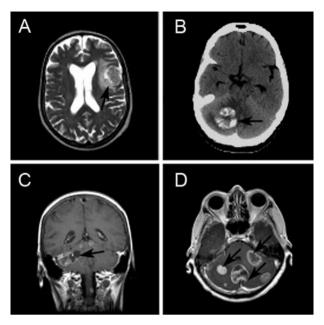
Cranial images of patients with brain metastases from ovarian cancer diagnosed at Medical University of Berlin. A, Axial magnetic resonance (MR) imaging of the brain (T2-weighted) showing a prominent tumor in the left parietal lobe with low density signal surounding the tumor mass representing an edema. B, Axial enhanced CT scan of the brain showing 33 mm right inhomogeneous cerebellar lesion with perifocal edema. C, Frontal MR imaging of the brain (T1-weighted) demontrates a right inhomogeneous cerebellar lesion with surrounding focal edema. D, Axial MR imaging of the brain (T1-weighted) demonstrates different inhomogeneous signal density compatible to multiple metastatic cerebellar lesions.
